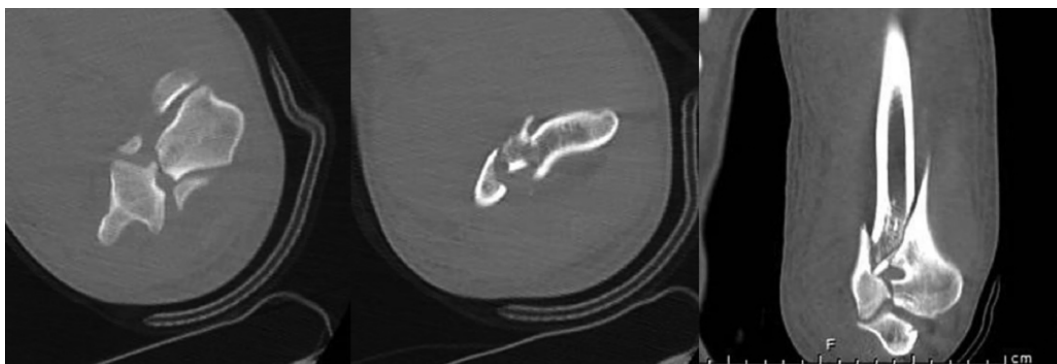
Axial and coronal images from CT scan further demonstrating the degree of intra-articular comminution and step-off.
